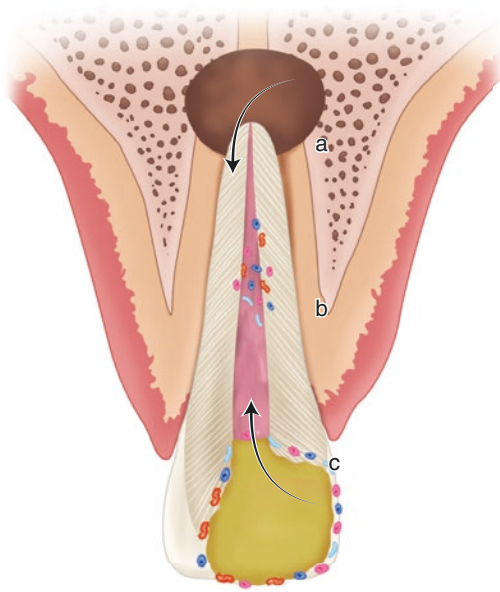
Three basic requirements from a root canal filling: (a) Guarantee a tight apical seal to prevent influx of periapical fluids, which may nourish surviving microbes in the root canal; (b) Isolate surviving microbes in the root canal space so that they cannot multiply and/or communicate with the peri-radicular tissues; (c) Stop coronal leakage after the root canal and crown is filled
